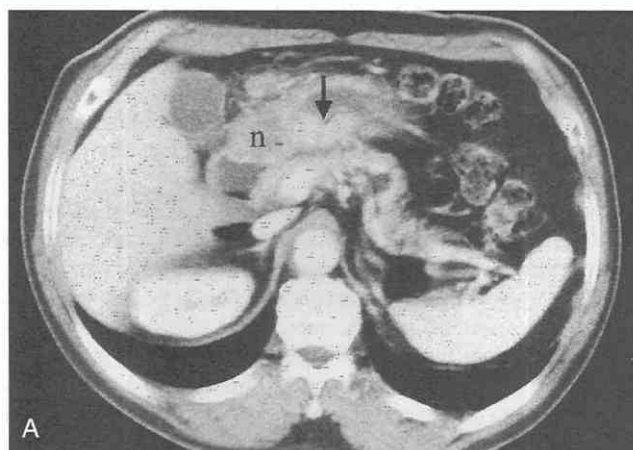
Gastric cancer with pancreatic invasion. A, CT scan shows obliterated interface (arrow) between the tumor in the stomach and pancreas along with linear strands. Enlarged perigastric nodes are also seen. B, Axial T1-weighted MR image at a lower level shows obliteration of the fat plane between the enlarged perigastric node and the uncinate process of the pancreas along with diffuse stranding. (From Sohn KM, Lee JM, Lee SY, et al: Comparing MR imaging and CT in the staging of gastric carcinoma. *AJR Am J Roentgenol* 174:1551–1557, 2000.)
